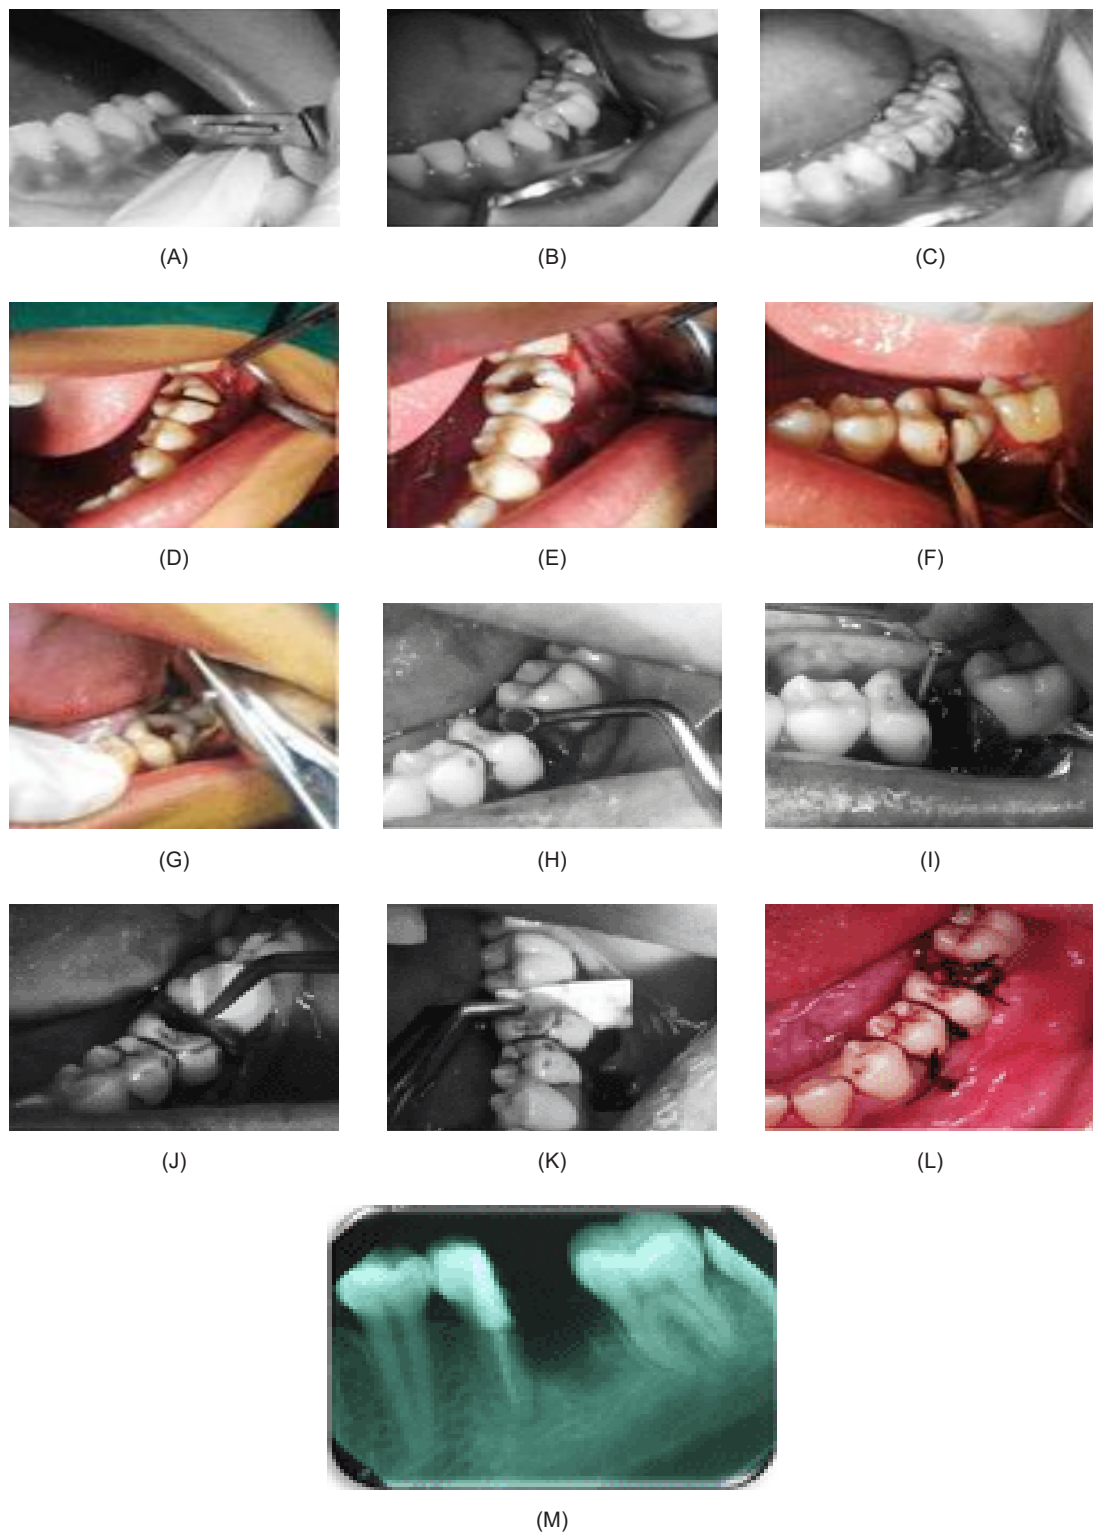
(A and B) Incision with a triangular flap design using blade no. 15; (C) Opening of the flap with a raspatorium; (D and E) Separation of tooth 36 from the crown to bifurcation, separating the tooth into two parts, namely mesial and distal; (F) Separation of the mesial and distal roots of tooth 36 with an elevator; (G) Distal root removal using mandibular molar root forceps; (H and I) Curettage of the distal root socket of tooth 36 followed by smoothing of the sharp part of the tooth; (J and K) Application of bone graft and membrane to the distal root socket of tooth 36; (L) Reposition of the flap followed by suturing using the interrupted suture technique; (M) Periapical radiograph after hemisection, the distal root of tooth 36 has been taken
